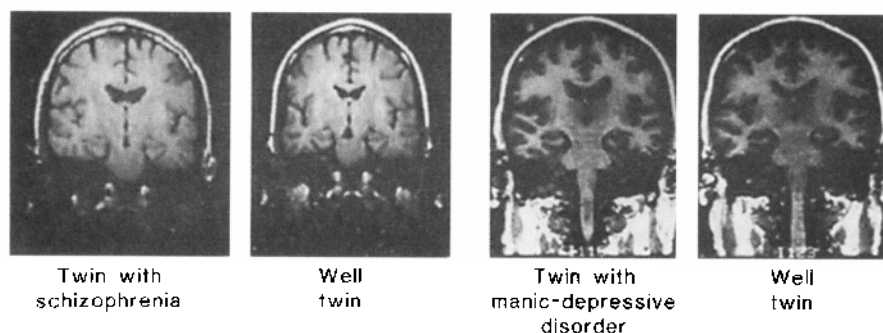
MRI scans of two pairs of identical twins showing enlarged cerebral ventricles in affected twins.
